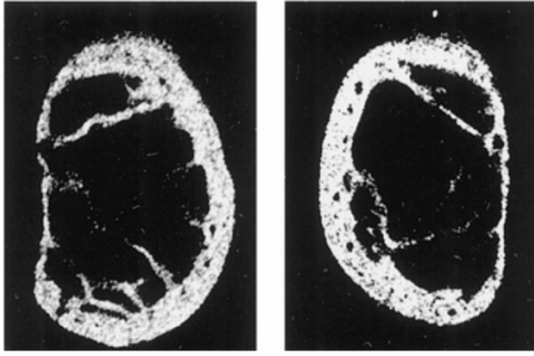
Radiographs of the left and right cervical pedicle in the coronal plane [35]
